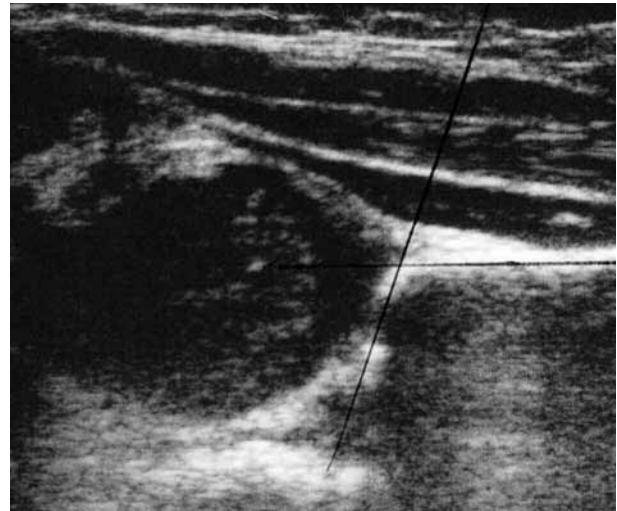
Case 2. Ultrasound of the right hip showing no evidence of subluxation or dislocation on dynamic assessment and an alpha-angle of 80 degrees.
